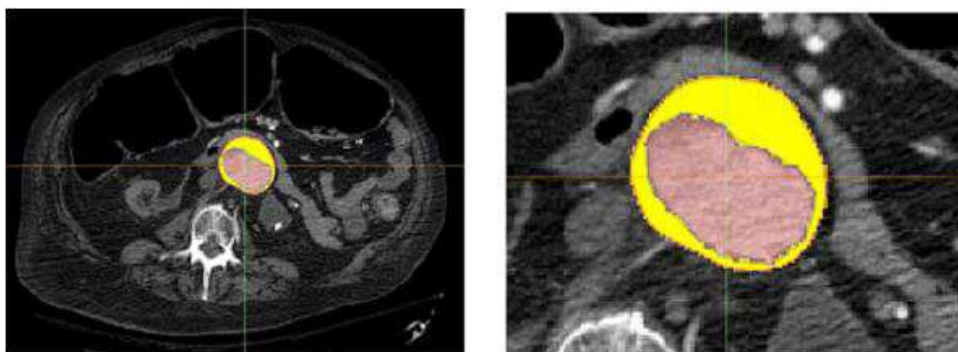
Segmentation and polyline generation of CT scan. (a) Full CT scan. (b) Close-up of the region of interest. From (Doyle et al., 2008)
